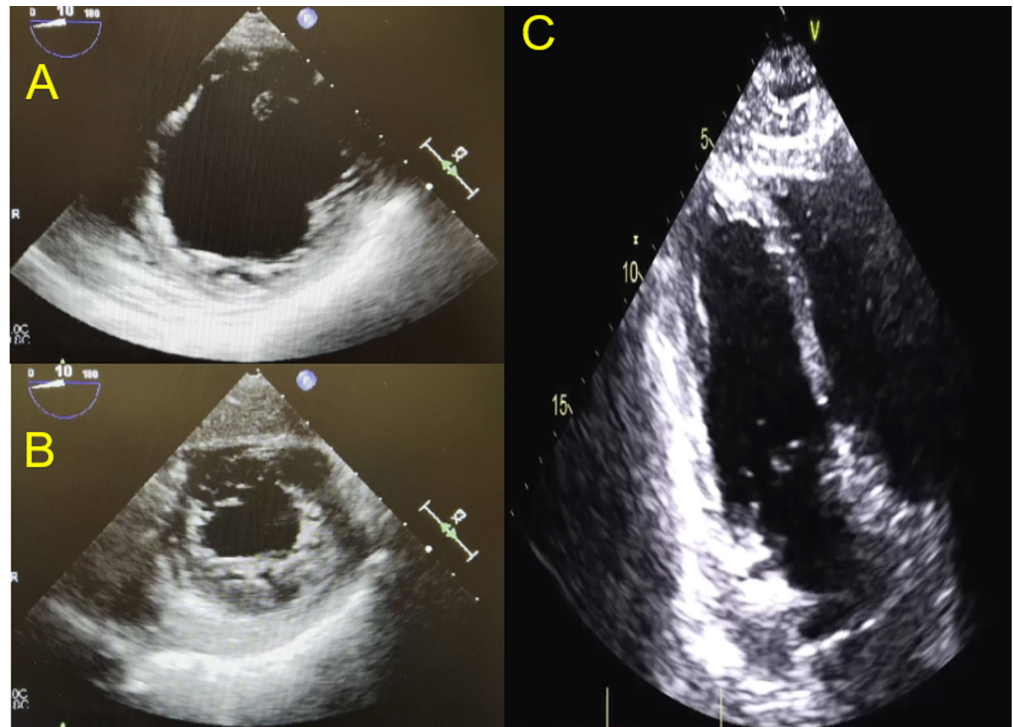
Intraoperative transesophageal echocardiography imaging of a transgastric mid-chamber short-axis view (A), and transgastric apical short-axis view (B). The images show severe mid-chamber akinesis (A) and apical hypokinesis (B), consistent with a reverse Takotsubo/stress-induced cardiomyopathy pattern. Post veno-venous extracorporeal membrane oxygenation on day 1 shows resolution of regional wall motion abnormalities in transthoracic modified apical 4-chamber view in Mayo Clinic format with the left ventricle on the left side of the screen (C) and a calculated 2-D biplane volumetric left ventricular ejection fraction of 59% per report.
